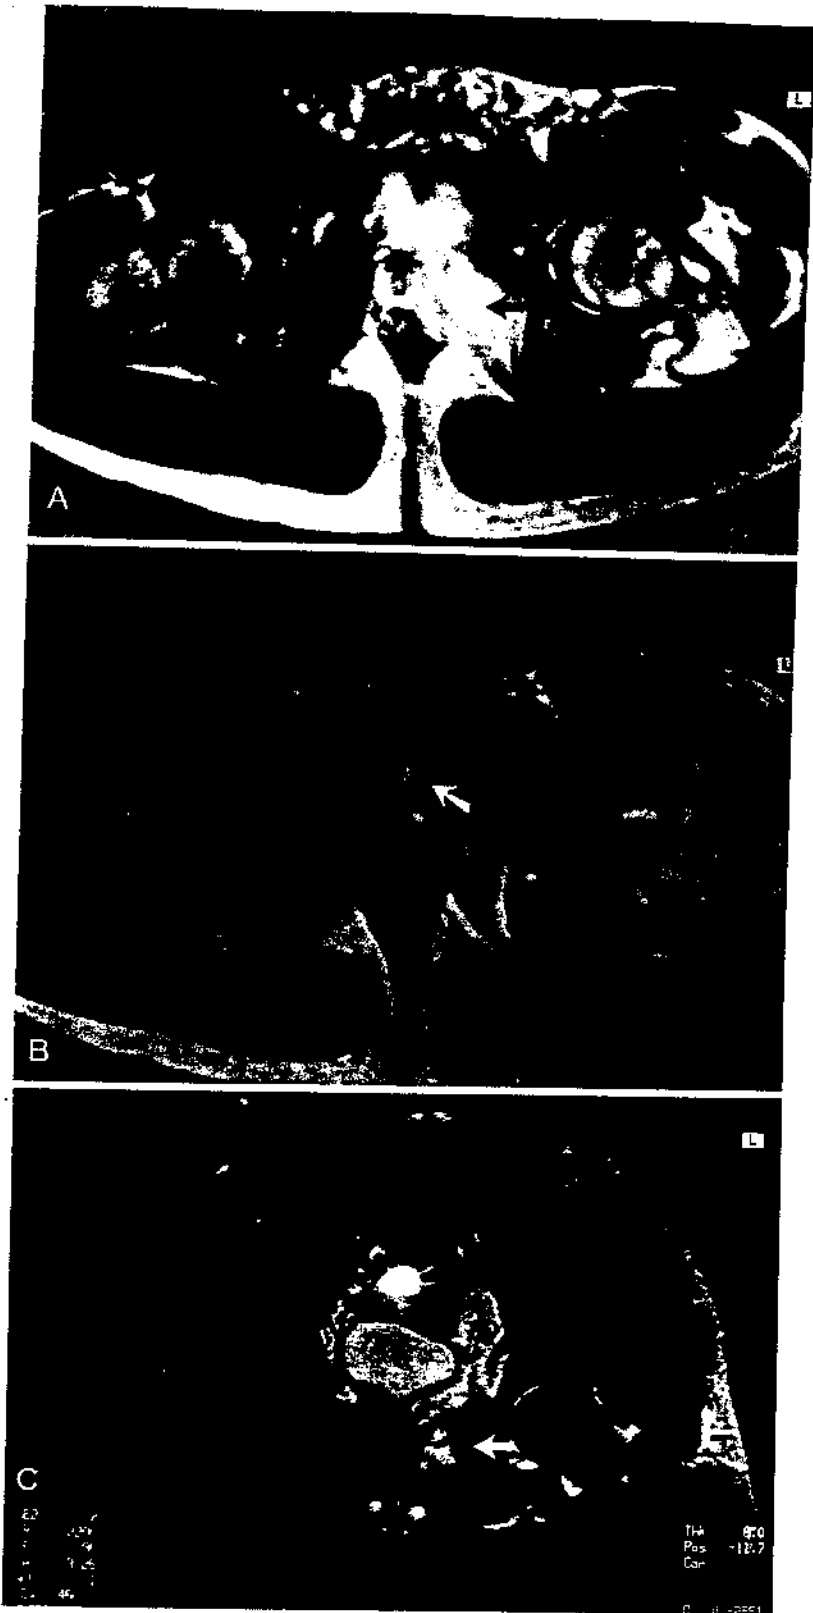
A) T2-weighted ( $T_E/T_R = 45/2200$ ) axial MRI of pelvis demonstrating increased signal in left obturator internus muscle representing edema. B) T2-weighted ( $T_E/T_R = 90/2200$ ) MRI of pelvis demonstrating increased signal and fluid in the symphysis pubis. C) T2-weighted ( $T_E/T_R = 90/2200$ ) coronal MRI of pelvis.
